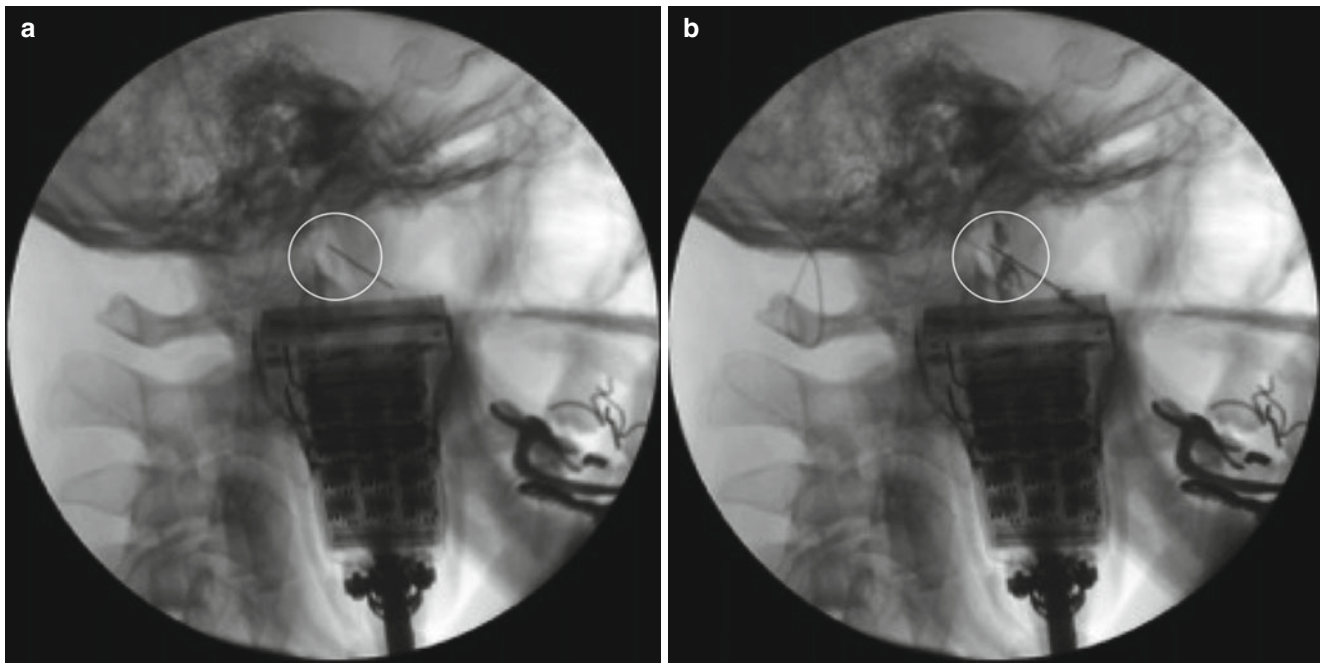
Combined fluoroscopy/ultrasound-directed pulse radiofrequency lesioning of the spinal accessory nerve (Image courtesy of Christ DeClerck, MD General Hospital Sint Jan, Bruges AV, Belgium)
